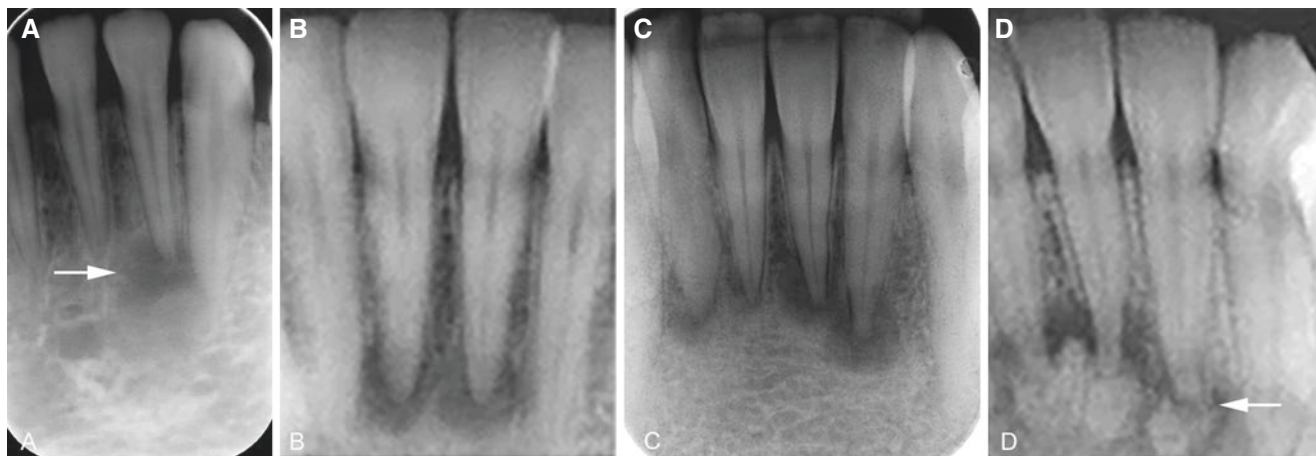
Periapical osseous dysplasias, mandible, incidental finding, vital teeth. Intraoral (periapical) views of incisors: (A) one periapical radiolucency (*arrow*), (B) two periapical radiolucencies, (C) four
